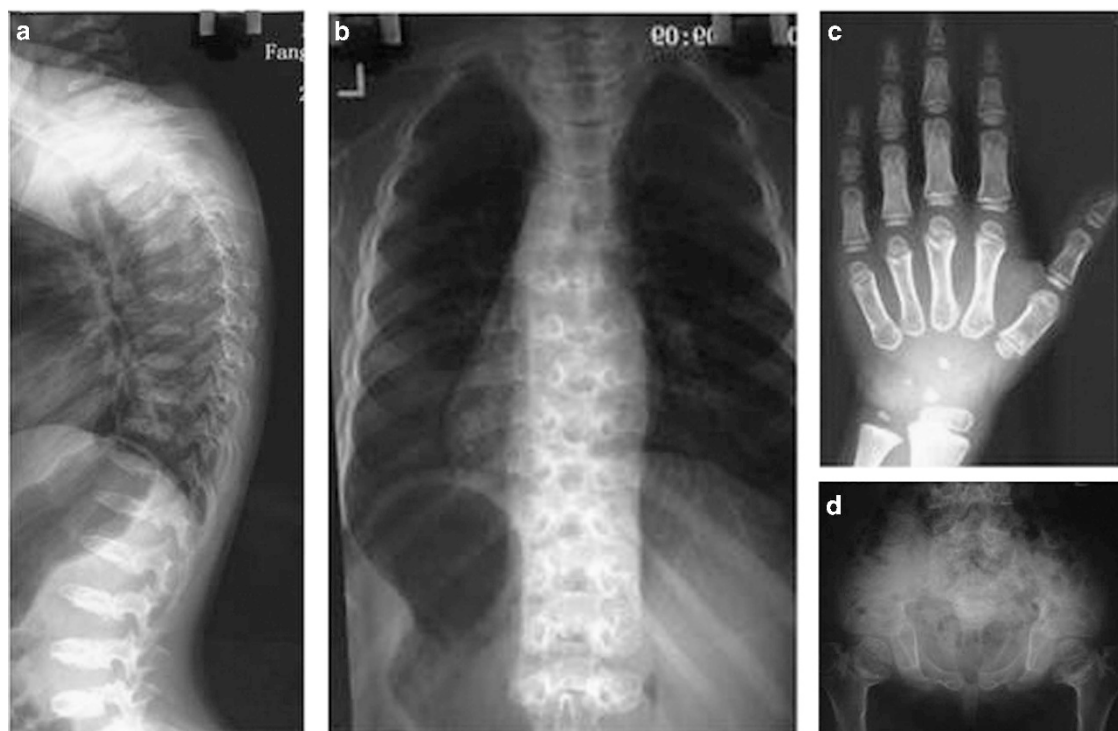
Radiographs of a girl with *TRPV4*-related spondylometaphyseal dysplasia. (a) Lateral view of the spine showed platyspondyly; (b) chest radiography showed mild oar-shaped ribs; (c) delayed carpal bone ossification in the left hand; (d) broad and short femoral neck indicated metaphyseal dysplasia. All the pictures were taken at the age of 4 years 5 months.
